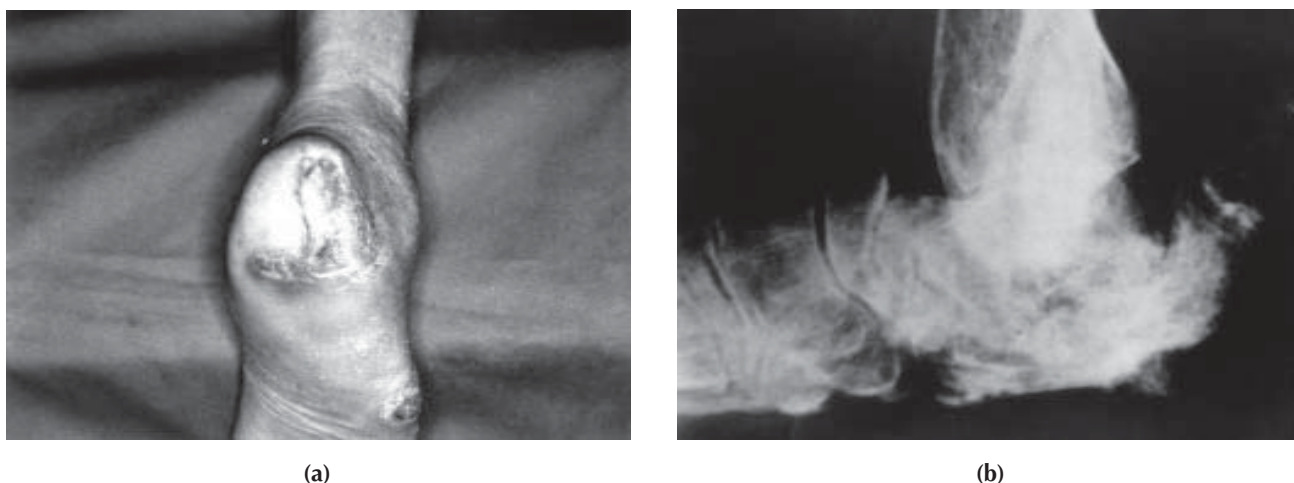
Case 2: findings following hyperbaric oxygen therapy (a) gross ulceration evident reduced (b) X-ray of the calcaneus showing induration in the pressurised destructive region of the calcaneus and repair of the bone.
